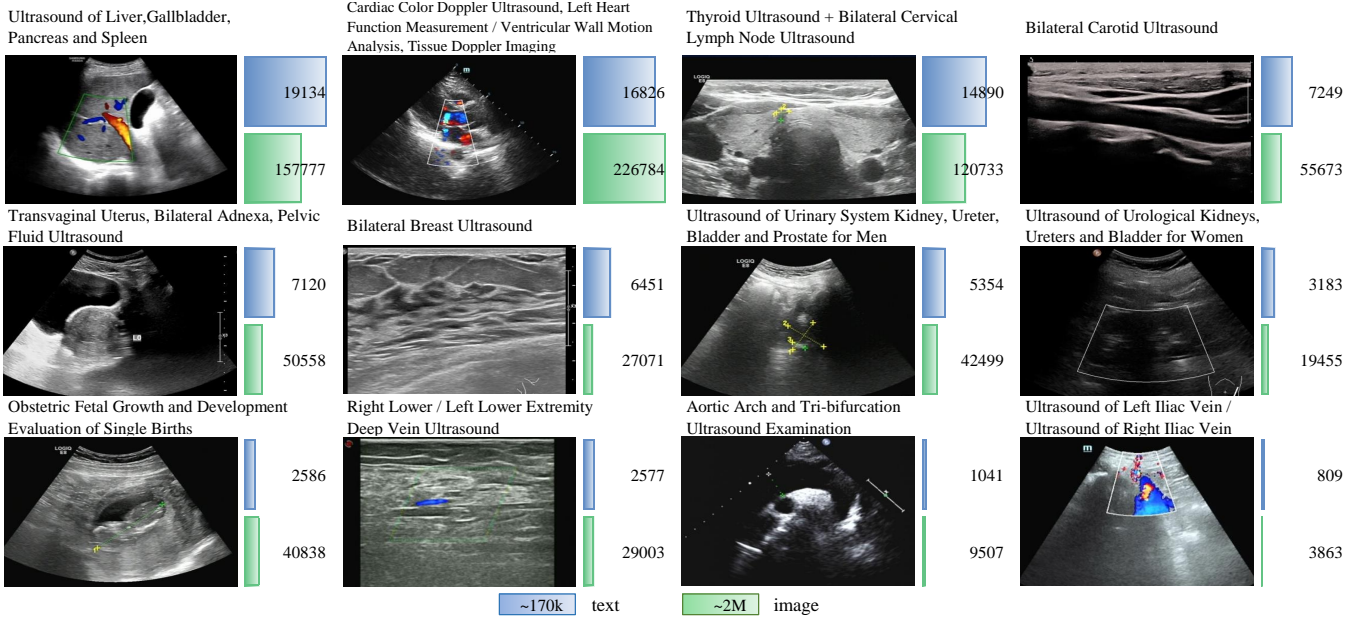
Some instances of our ultrasound dataset from the hospital (US-Hospital), where the numbers represent the counts of items of text and images.
